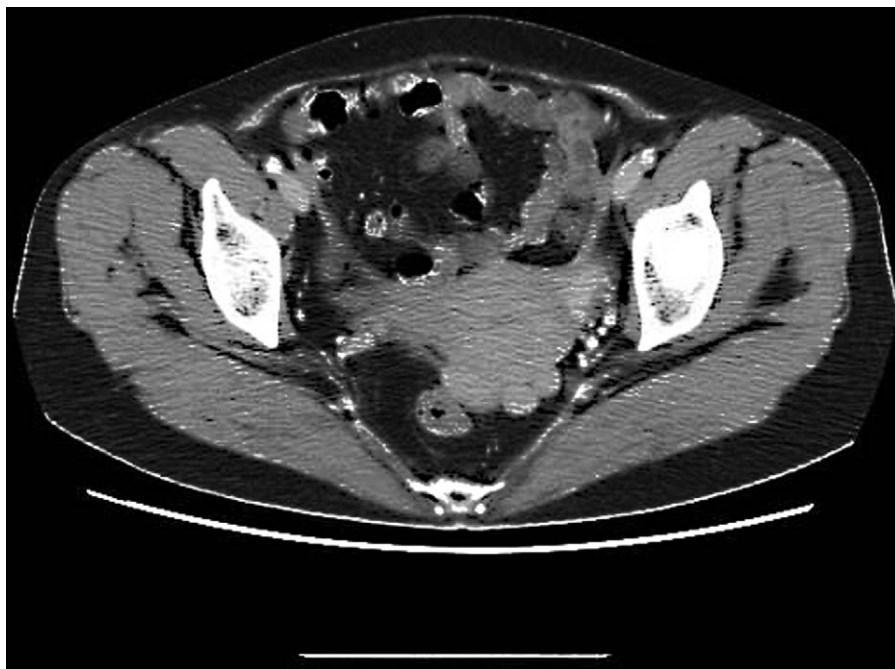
In a 49-year-old woman with splenosis of douglas fossa, computed tomography of the pelvic cavity (axial view) showed multiple soft-tissue shadows with no enhancement.
